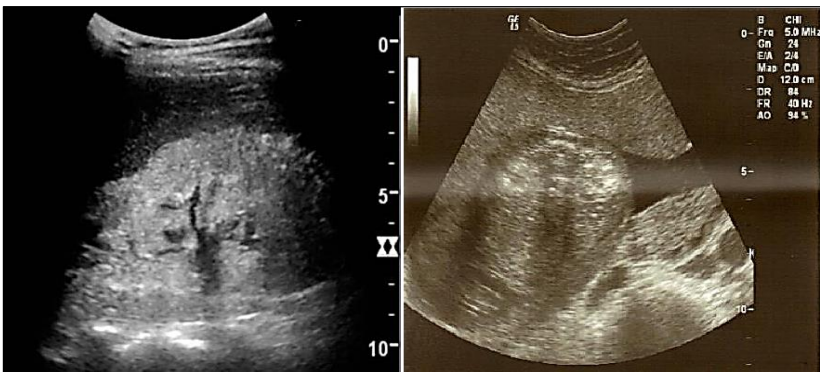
Nephrotic syndrome ultrasonography
